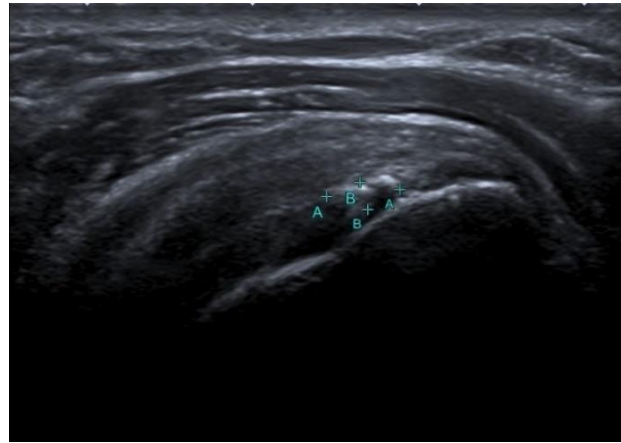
An example of ultrasound images with annotations.
